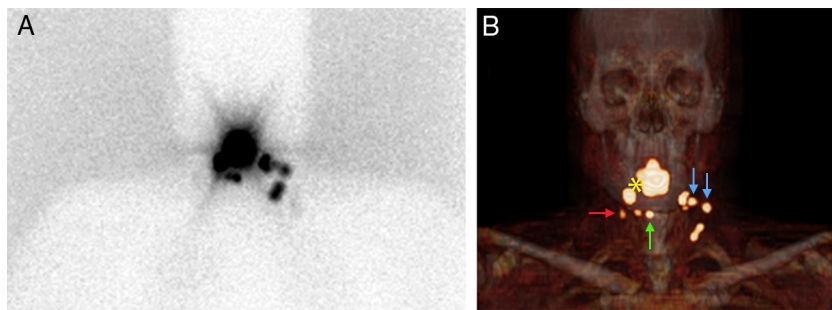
Preoperative SLN identification. (A) Later static scintigraphic images show drainage to right and left laterocervical and midline cervical areas on anterior projection. (B) The 3D volume rendered SPECT/CT study shows one SLN on the right laterocervical side at level Ib (red arrow), located caudally to the injection site of the radiopharmaceutical (asterisk), and one SLN on the midline cervical region at level Ia (green arrow). Moreover, two SLNs are seen on the left laterocervical side at level IIa (blue arrows), despite there is a hotspot located medially to them which is considered a lymphatic tract as it is seen as a linear uptake in other projections.
